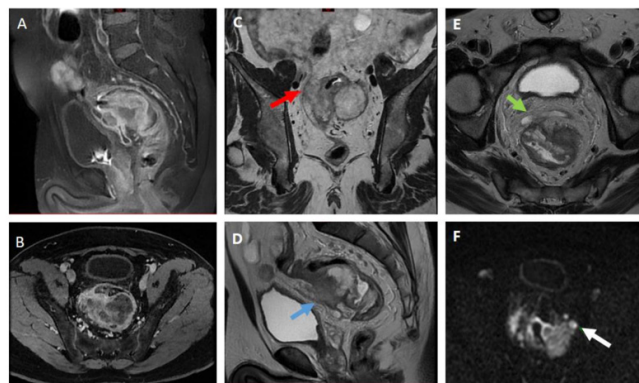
MRI of patient DO VAN M. (Case 2) with high rectal cancer cT4aN2aMx.
